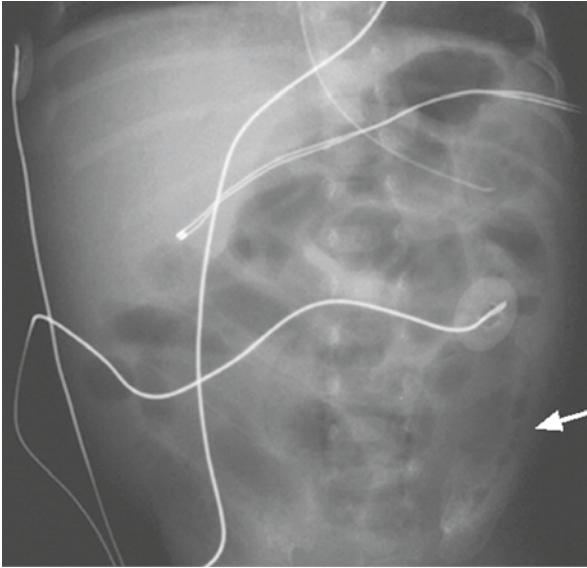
Abdominal X-ray: pneumatosis intestinalis (arrow)
